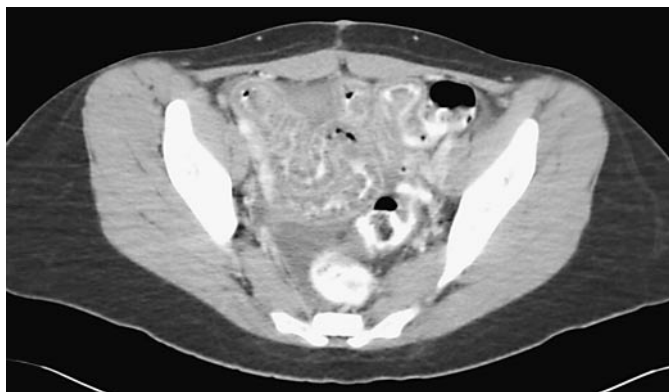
Crohn's disease in a 17-year-old male. The contrast-enhanced axial CT reveals diffuse ileal wall edema and mural stratification. Free fluid is also seen in the pelvis.
